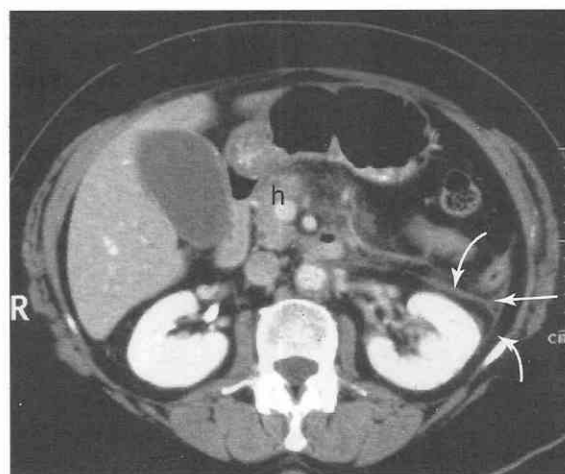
Axial CT scan shows that the head (*h*) of the pancreas is normal but the body and tail are atrophied. Also note that chronic infection has produced thickening of the lateroconal fascia (*straight arrow*) and the perirenal fascia, both anterior and posterior (*curved arrows*).
